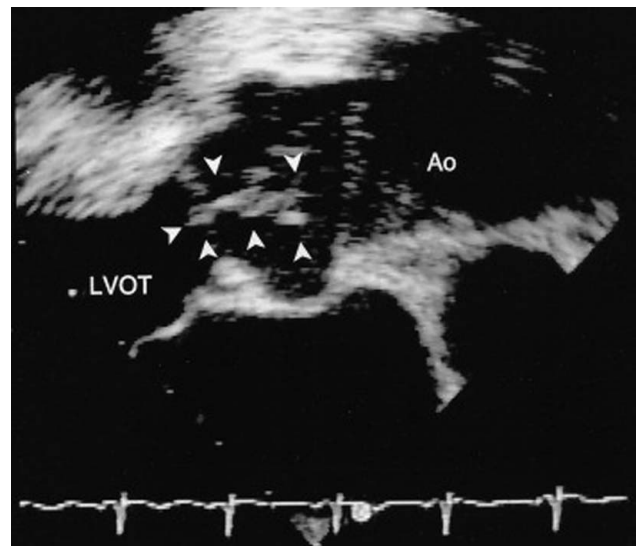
Transesophageal echocardiogram showing a cardiac on the aortic valve. Zoom view of an aortic valve papillary fibroelastoma (arrowheads), showing the linear morphology, with strands visible. Ao, aorta; LVOT, left ventricular outflow tract.
